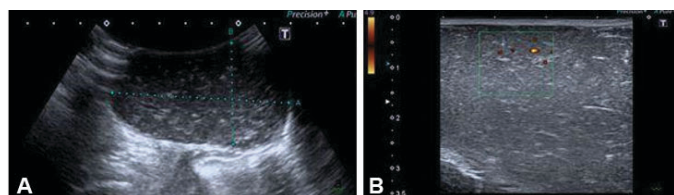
Ultrasound images showing. (A) A well-defined oval-shaped heterogenous lesion with internal linear echogenic foci. (B) No flow on Doppler examination.
